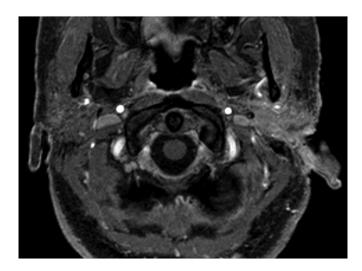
Cerebral MRI with contrast. Left middle ear cavity is occupied by tissue with disomogeneous signal and contrast enhancement, with extension to periauricular soft tissues, external auditory canal walls and anterior pericondilar tissues. Cystic and necrotic aspects can be noticed. Tissue is described as inflammatory as first hypothesis.
